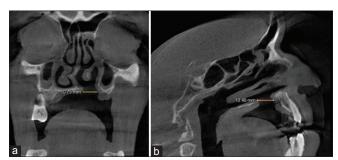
(a) Coronal and (b) Sagital Cone Beam CT view revealed intact maxillay sinus but discontinuous nasal floor
